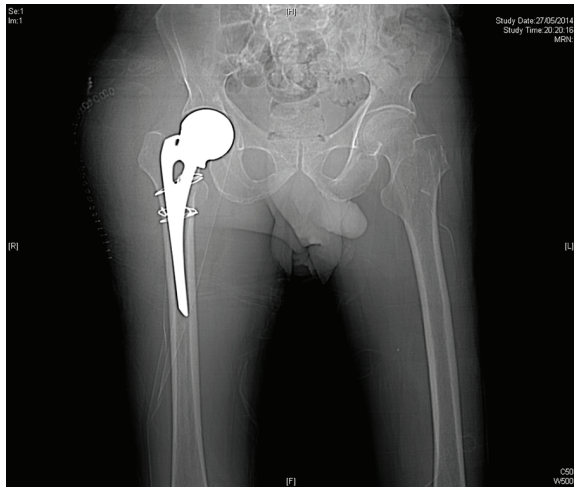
Post-operative X-ray pelvis showed good alignment and the patient started protected weight bearing walking on post-operative day 3.
